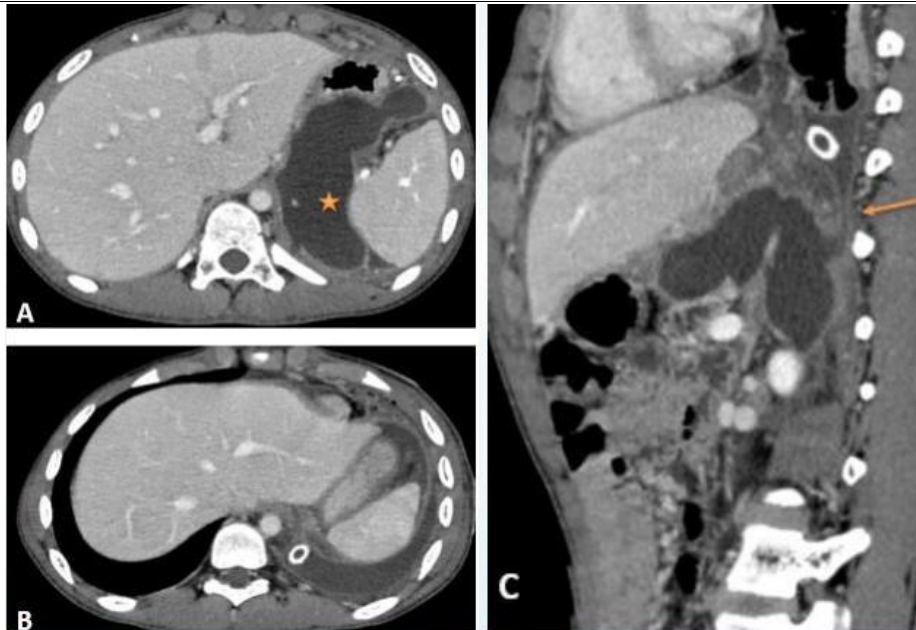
Contrast-enhanced CT images (A, B – axial; C – sagittal) demonstrating a peripherally enhancing collection in the gastrosplenic region abutting the left hemidiaphragm (star), with a focal diaphragmatic defect and superior extension into the left pleural cavity (arrow), resulting in loculated left-sided pleural effusion—features consistent with pancreatico-pleural fistula.
